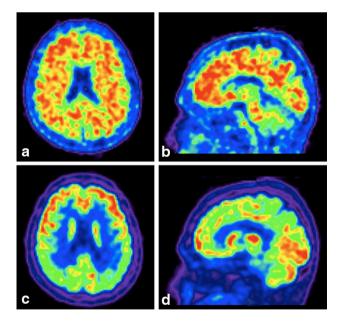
Example case of a patient (53 years old, education >18 years) with mild cognitive impairment and both amyloid PET (a, b) and FDG PET (c, d) positive. a, b amyloid PET shows widespread cortical A $\beta$  accumulation in both hemispheres. c, d FDG PET shows reduced metabolic activity in temporo-parietal regions, in precuneus and posterior cingulate cortex
